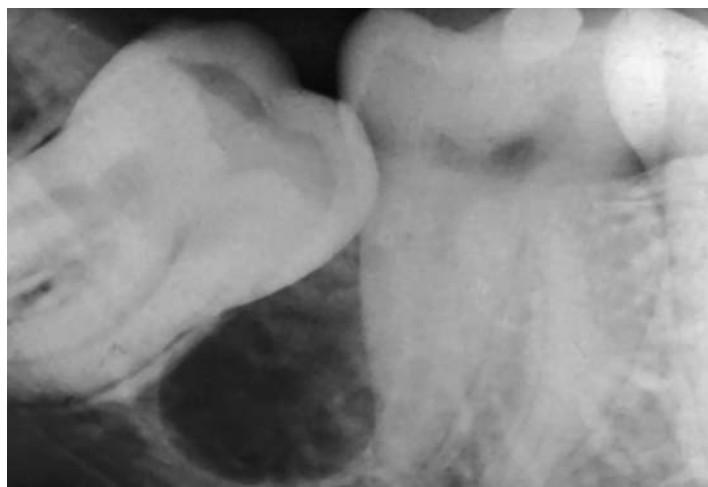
Radiograph of a lateral type of dentigerous cyst.
